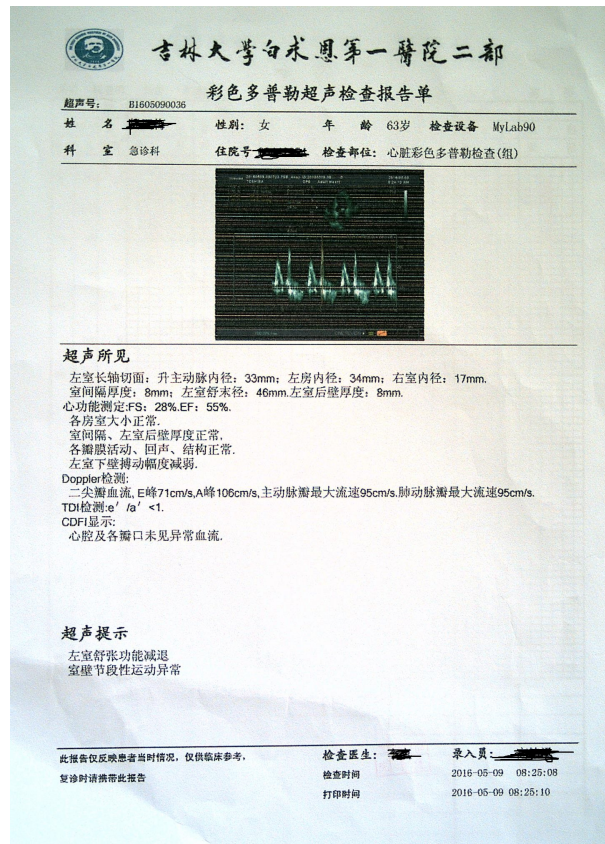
Echocardiography in diagnosis of acute myocardial infarction
